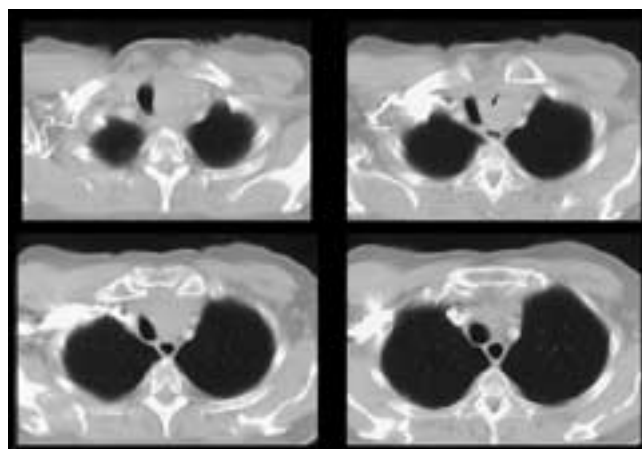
Goiter. A 75-year-old man with hyperthyroidism. Contiguous contrast-enhanced axial images from a CT scan demonstrate a 4 × 5 cm diameter left thyroid mass (*arrow*), which flattens and deviates the trachea toward the right. An adenomas goiter was discovered following partial thyroidectomy.
